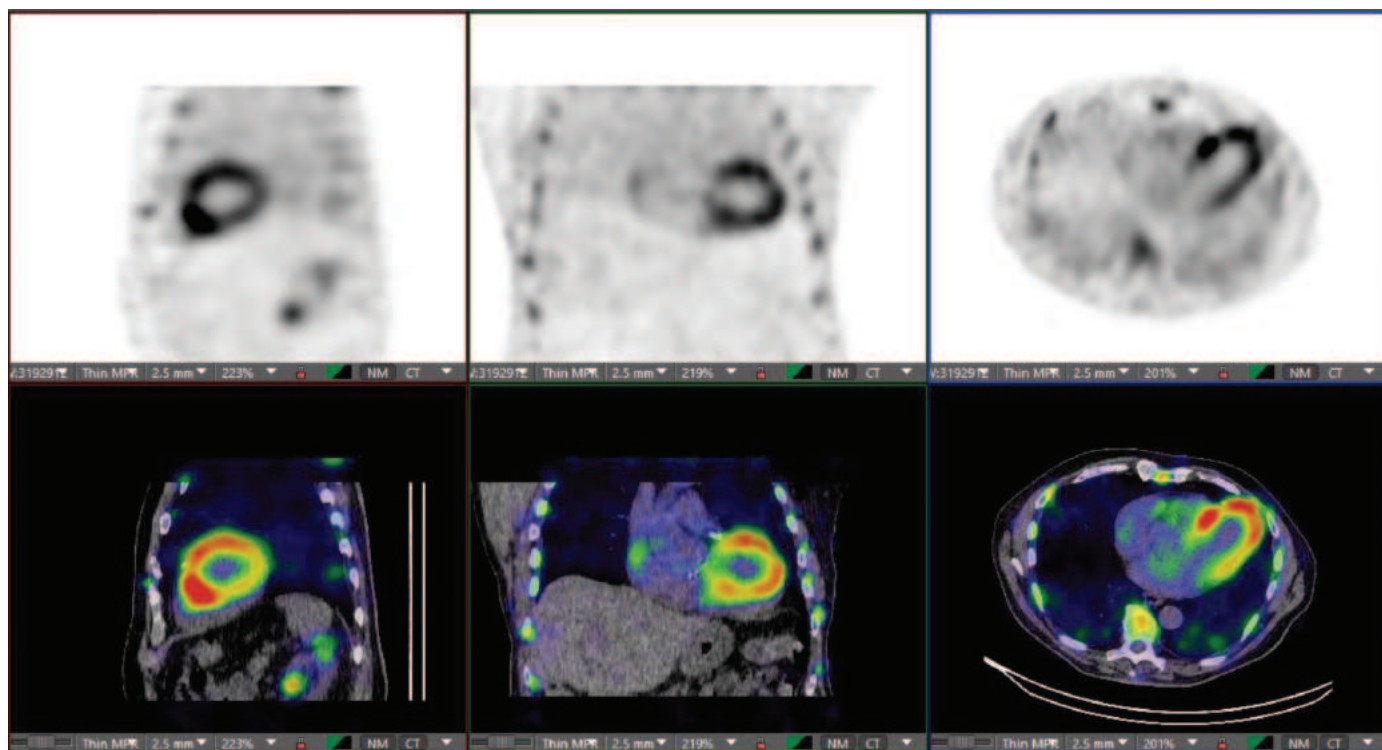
Technetium pyrophosphate (PYP) scan in a patient with wild-type transthyretin amyloidosis. The top three images are obtained in three separate views with single-photon emission computed tomography (SPECT) imaging alone, and the bottom three views with added cardiac CT imaging. Both modalities show marked myocardial uptake (*orange*) with absence of blood pool uptake (central clearing) and normal bone uptake. The lower images more precisely localize the uptake to the fused CT images of the heart, which in more equivocal cases helps to localize uptake to the myocardium and prevents misinterpretation as a positive scan due to blood pool uptake without myocardial uptake. PYP uptake is highly sensitive and specific for transthyretin amyloidosis but can occasionally be present in AL amyloidosis; thus, exclusion of a plasma cell dyscrasia is mandatory when interpreting this imaging. In the normal heart and almost all other pathologies, there is no myocardial uptake of bone tracers such as PYP.
